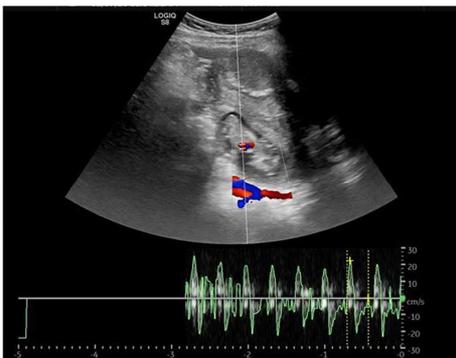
Pulsed and color Doppler exam showing viable twin ectopic pregnancy with positive heart beats.
